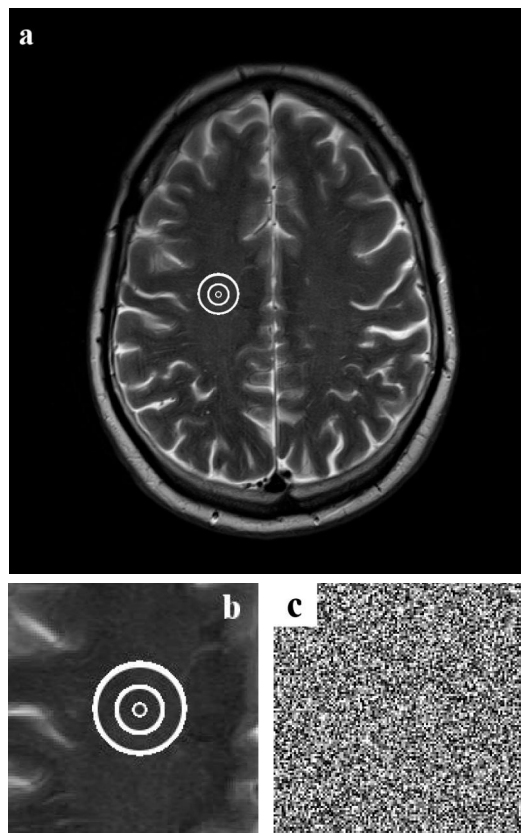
Examples of a magnetic resonance image and regions of interest on the centrum semiovale (a), zoomed regions of interest of size 5, 20, and 35 pixels in diameter (b), and artificial noise image with random pattern (c).
